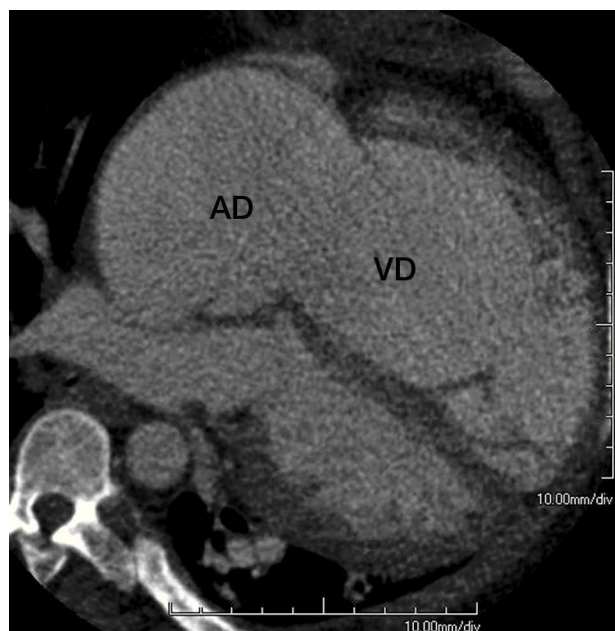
Multiplanar reformation in a 4-chamber view orientation of cardiac computed tomography in a patient with severe right atrial (RA) and right ventricular (RV) enlargement due to tricuspid regurgitation.
